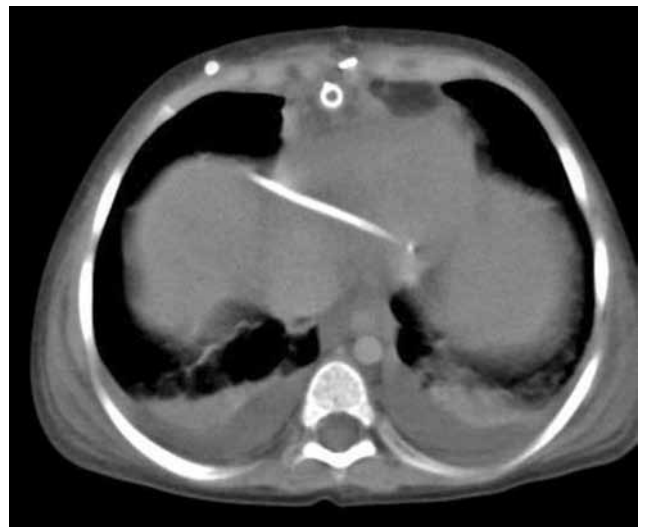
Computed tomography showing the shunt catheter tip in the pericardial cavity along with pericardial effusion.
